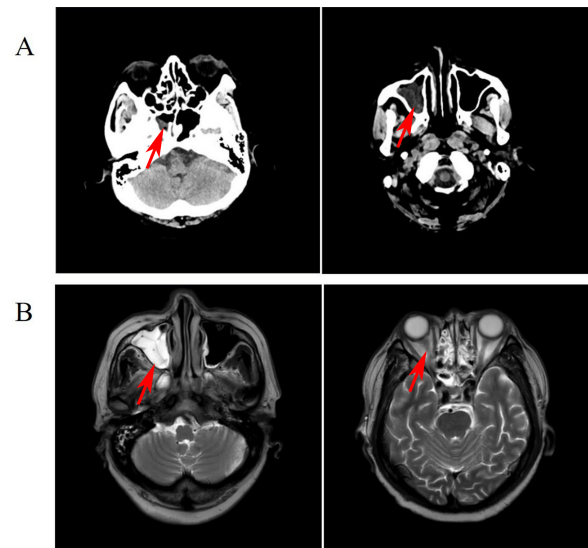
Imaging findings in the patient. (A) Cranial computed tomography findings show mucosal thickening in the bilateral maxillary and sphenoid sinuses with diffuse mucosal thickening in the bilateral ethmoid sinuses. Fluid density is observed in the right maxillary and sphenoid sinuses. The left arrow indicates fluid accumulation in the right sphenoid sinus, and the right arrow indicates fluid accumulation in the right maxillary sinus. (B) Cranial magnetic resonance imaging shows mucosal thickening in the bilateral frontal, ethmoid, sphenoid and maxillary sinuses, with more prominent thickening in the right maxillary sinus. The left arrow points to mucosal thickening in the right maxillary sinus, and the right arrow points to oedema in the right optic nerve.
